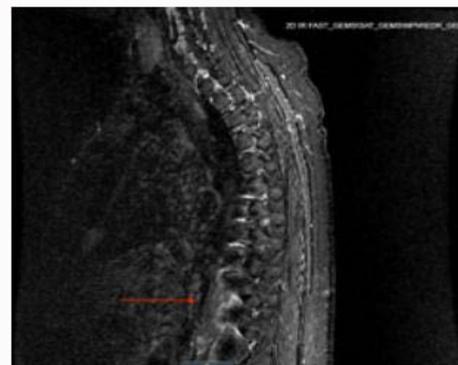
MRI of spine showing phlegmonous prevertebral collection extending from T10-L1.
